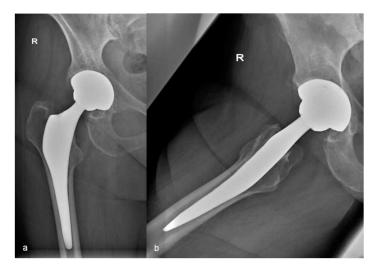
Postoperative x-rays a.p. and axial: correct position of the implanted, cementless total hip endoprosthesis.
